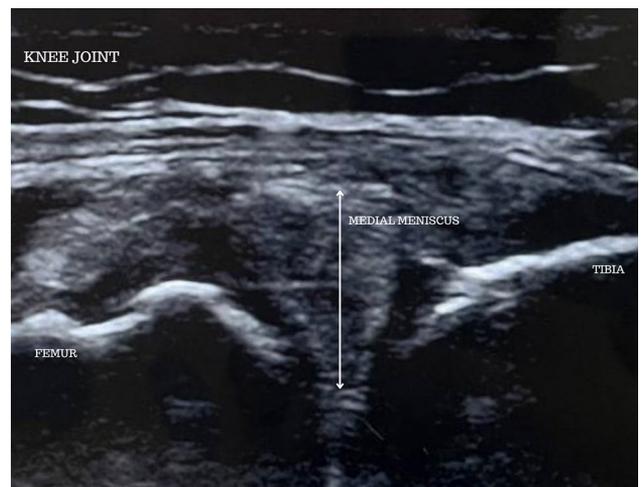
Appearance of medial meniscus protrusion in the musculoskeletal ultrasound of osteoarthritis knee.
